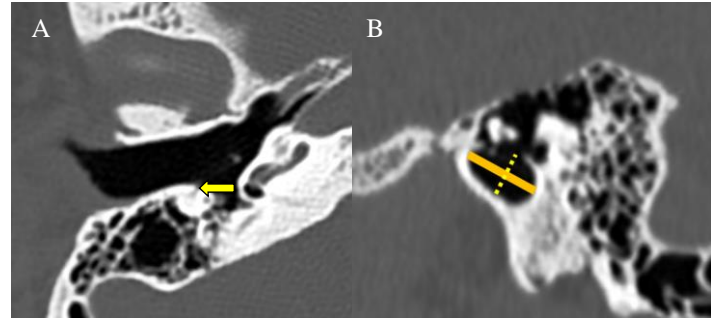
Axial CT image of temporal bone. 1st measurement point is at the level of the tympanic membrane where chorda tympani leaves the bony canal (yellow arrow), 1B: Sagittal CT image of temporal bone diameters at the level of the tympanic membrane where chorda tympani leaves the bony canal (1a: non-interrupted line, 1b: interrupted line)
